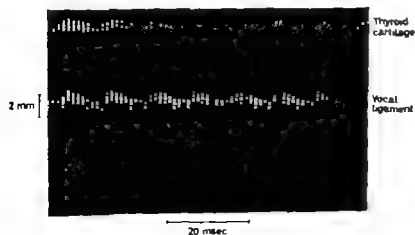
Ultrasonic recording of the vibrating vocal folds obtained with the apparatus shown in Fig. 3.
